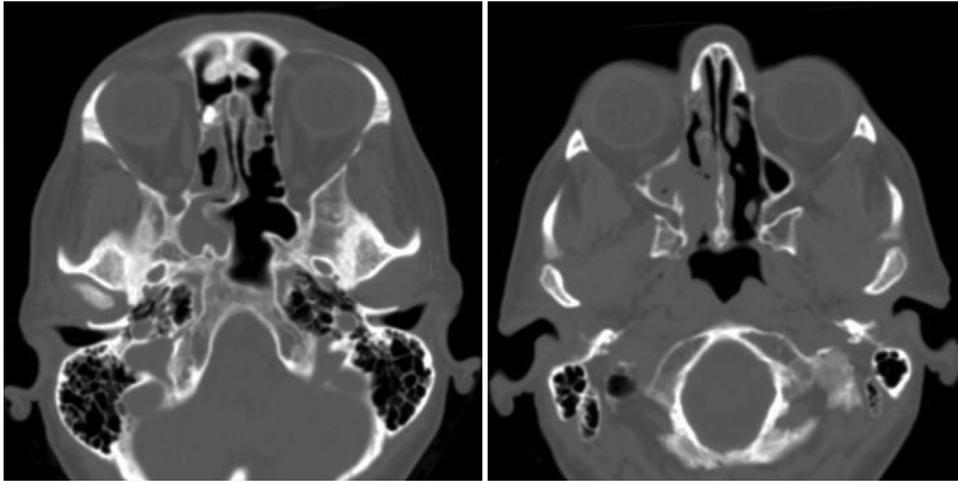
Representative axial sections of a head computed tomographic scan taken preoperatively that revealed no intracranial abnormalities but extensive mucosal thickening in the right maxillary sinus, right ethmoid air cells, and right sphenoid. Coronal views were unavailable.
